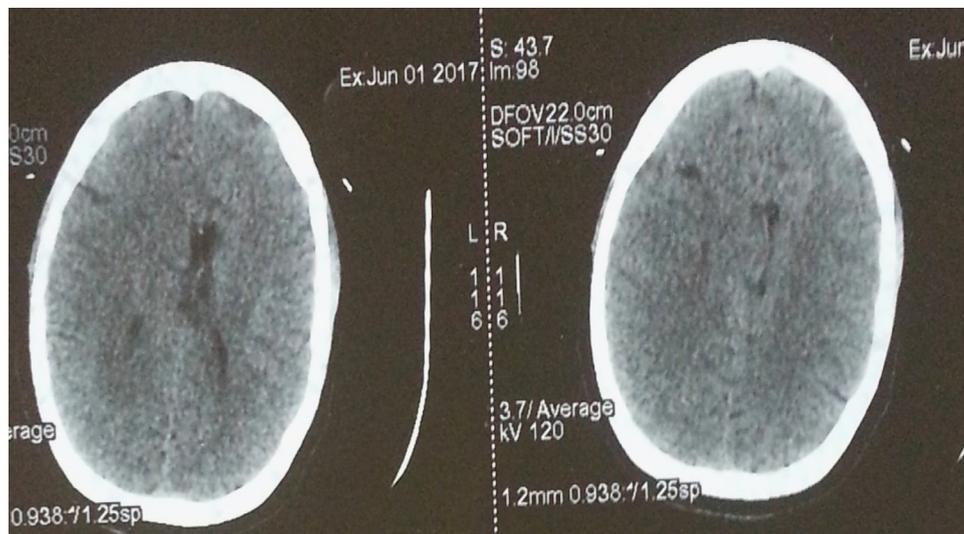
CT images revealing a discreet deviation of the median line to the left.
